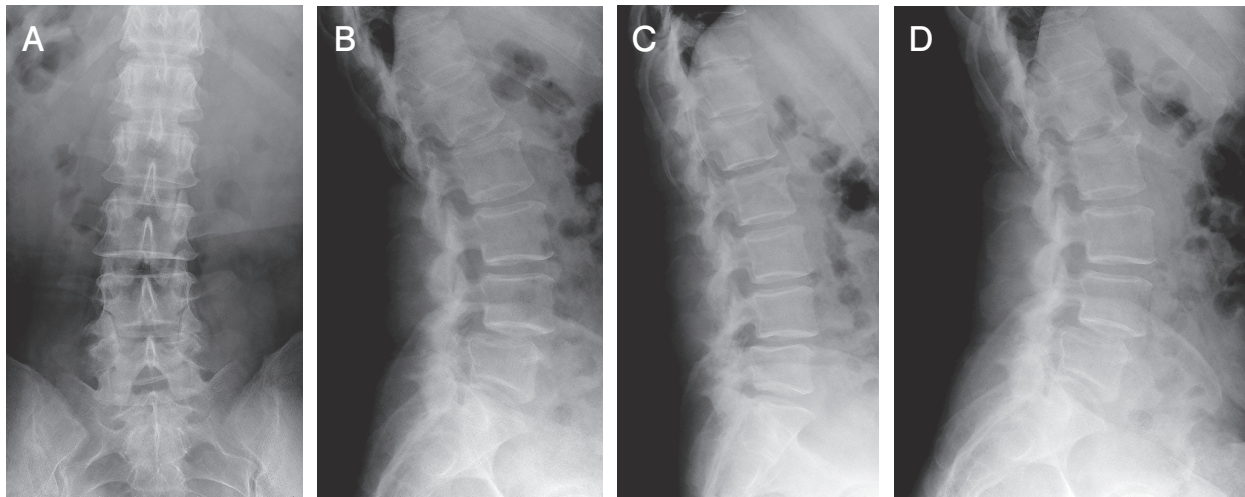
Preoperative lumbar radiographs. There is mild spondylolisthesis at the L4 level and instability at the L4/5 level. A, Anteroposterior view; B, Lateral neutral position; C, Lateral flexion view; D, Lateral extension view.
